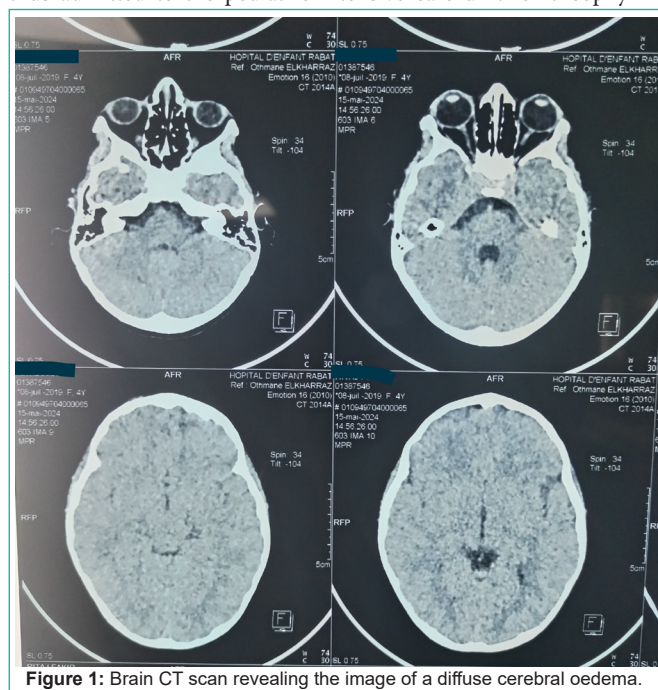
Brain CT scan revealing the image of a diffuse cerebral oedema.
